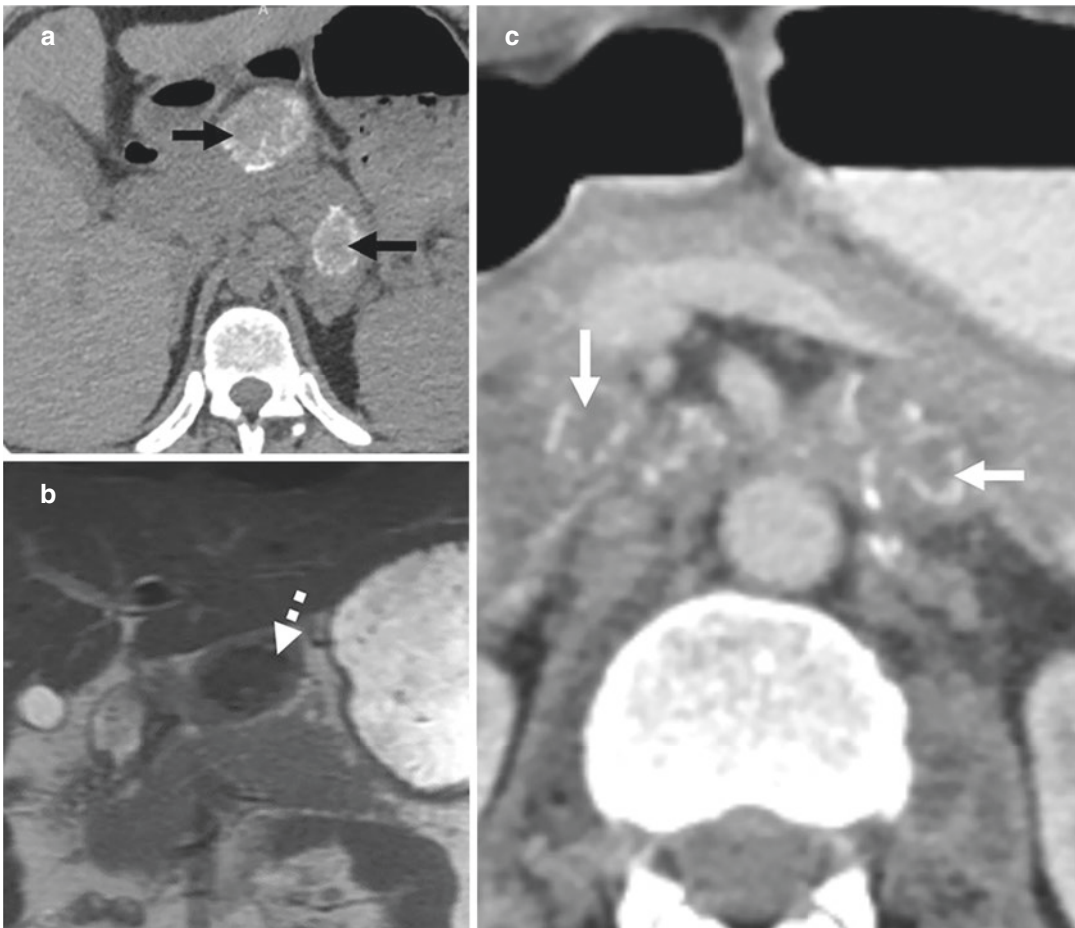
Tuberculous lymphadenitis. (a) Axial unenhanced CT, (b) coronal T2-W MR, and (c) axial contrast-enhanced CT images show small and large centrally (black arrows) and peripherally (white arrows) calcified nodes in the coeliac, splenic, and lesser curve nodal regions. The large
